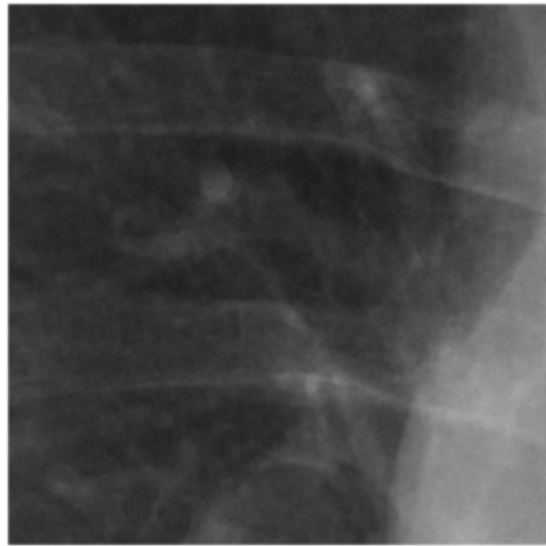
A detail in the lung of a patient chest X-ray image after addition of Gaussian noise, with 0 mean and variance computed in order to achieve a decrease of the estimated SNR by 30%.
